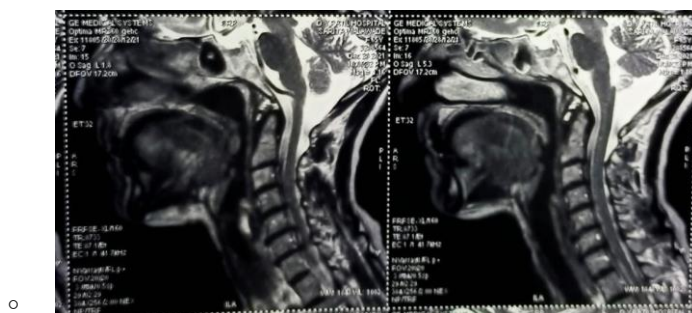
showing sagittal section of T2-weighted and STIR images from MRI of tongue MRI(contrast study) showed heterogenous enhancements in coronal and axial sections as seen in the figures 6 & 7 below
